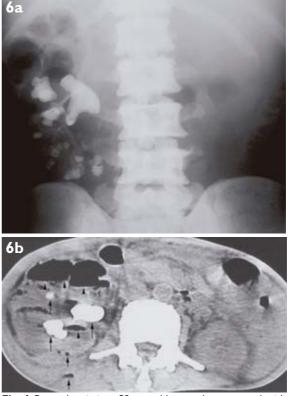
Pyonephrosis in a 58-year-old-man who presented with fever and right flank pain. (a) Abdominal radiograph shows an enlarged right kidney with multiple stones and prominent bubbles of gas. (b) Unenhanced axial CT image shows multiple stones (long arrows) and air-fluid levels (arrowheads) in the dilated calyces. Extension of gas (short arrows) into the posterior pararenal space and paravertebral muscle is also shown.
